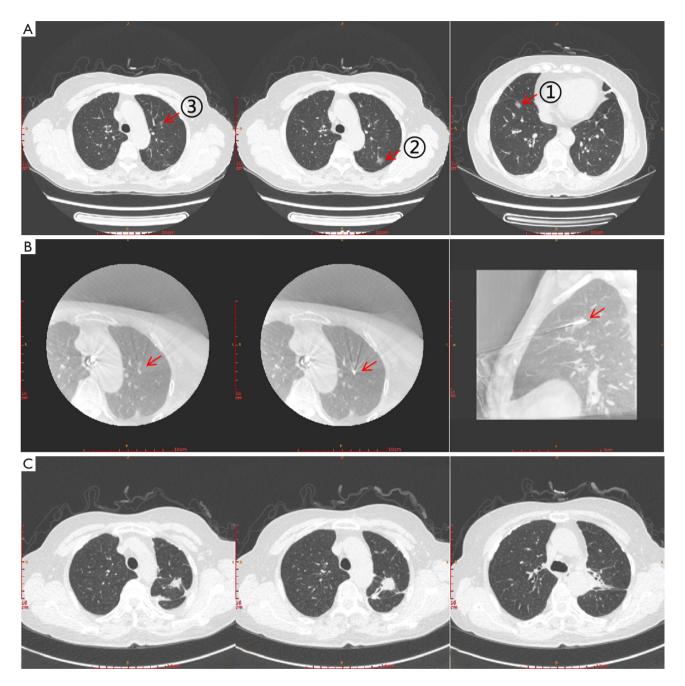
Images of chest CT scanning in case 1. (A) Pre-surgery scanning showed nodule 1 to 3 (n1 to n3, red arrows, marked as $\mathbb{D}(2)(3)$). Nodule 1 is a pure GGN and located in the anterior segment of left upper lobe, with maximum diameter of 0.7 cm. Nodule 2 is also a mixed GGN with maximum diameter of 1.2 cm, which located in the apicoposterior segment of left upper lobe. Nodule 3 is a mixed GGN located in the anterior basal segment of right lower lobe, with maximum diameter of 1.2 cm. (B) Images of intraoperative localization of n1 under real-time guide by a C-arm X-ray. This nodule was treated by microwave ablation with the help of intraoperative localization under real-time guide by a C-arm X-ray machine. Red arrows show the position of the ablation needle tip. (C) CT images of two months after first-stage surgery. In this surgery, nodule 1 was treated by microwave ablation and nodule 3 was treated with segmentectomy of LS_{1+2a} . CT, computed tomography; GGN, ground glass nodule.
